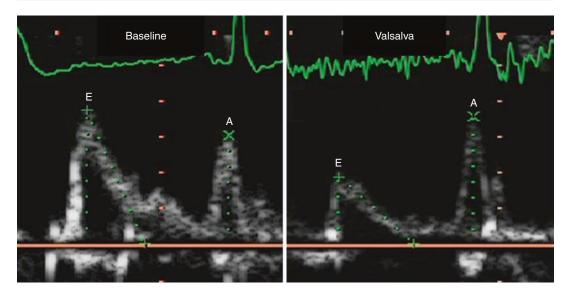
Shown is mitral inflow pulsed Doppler with the sample volume at the leaflet tips; the left panel demonstrates what is a "pseudonormal" pattern that is unmasked with the Valsava maneuver on the right panel; note the change in the early mitral inflow velocity (E wave) from
